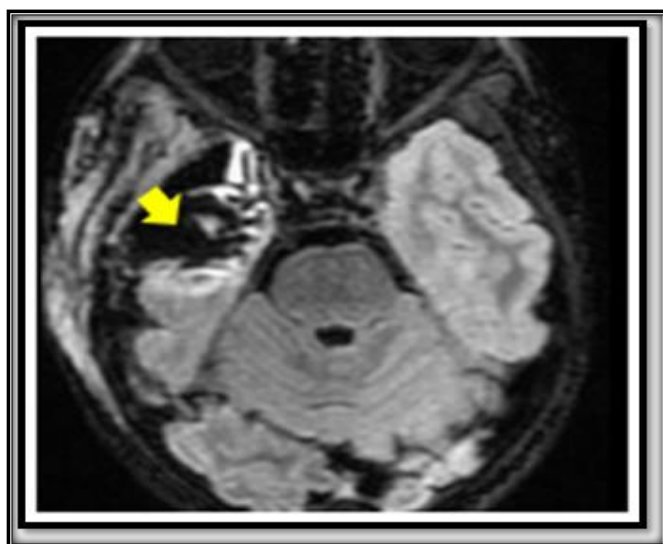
Axial FLAIR image showing postoperative changes in the right temporal lobe and hippocampus regions (yellow arrow).
